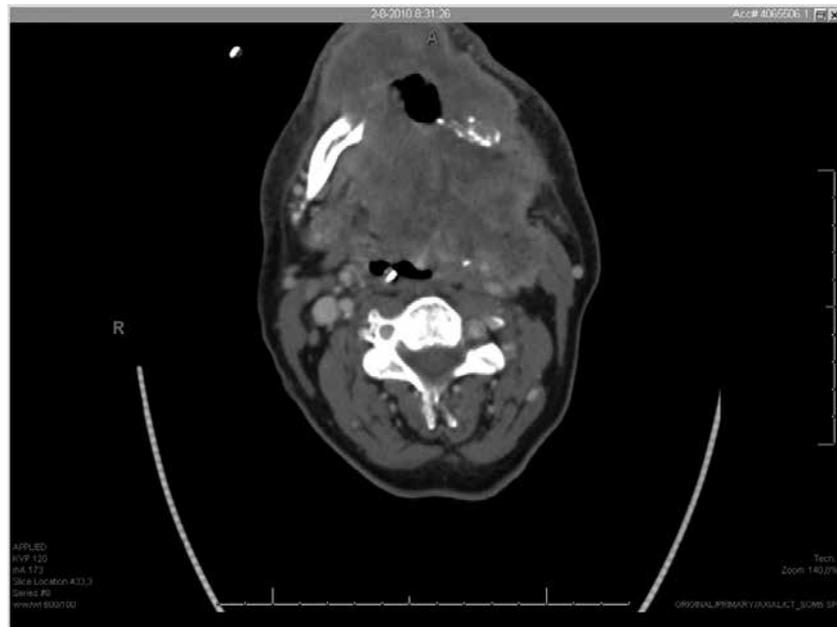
A prior CT scan showed a large tumour extending on the left side from the oropharynx, invading the mandible all the way down to the thyroid cartilage.
